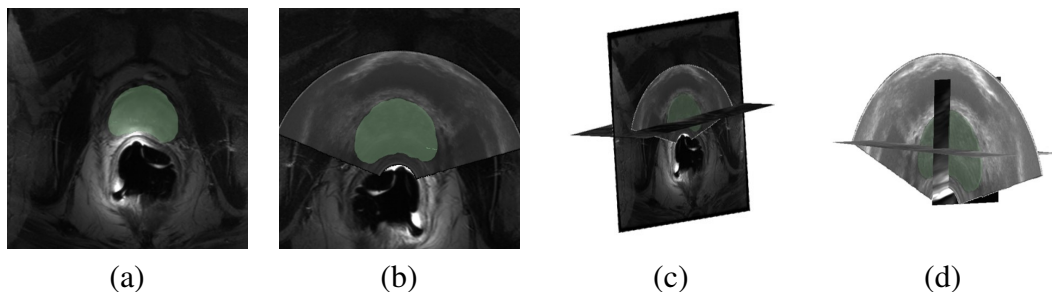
Various visualizations of prostate imaging are presented in this Figure. Image a) depicts an US slice from a 3D volume registered and overlaid on an MRI from the same patient, Image b) shows a prostate segmentation from the US overlaid onto the MRI image, figure c) shows a MPR visualization with three MRI slices intersecting the prostate segmentation, and figure d) shows a MPR visualization where a front-facing US image and two slices from the MRI are intersecting the segmentation.
